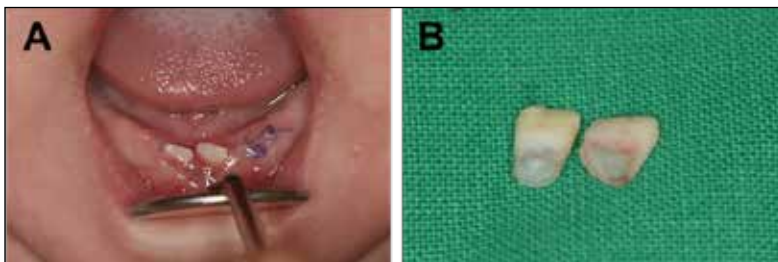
(A) Intraoral image of residual neonatal teeth showing yellowish color and cone-shaped. (B) Periapical radiograph of tooth-like structures showing periapical inflammatory lesion. (C) Micro CT image on #81 showing root canal structure and lack of coronal part. (D) Micro CT image on #71 also showing root canal structure with partial destruction on crown part.
